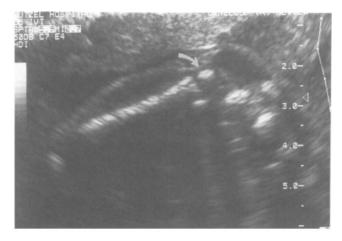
Patient 2, ultrasound imaging of the fetal femus at 21 weeks of gestation demonstrates echogenic epipheses (arrow) suggestive of premature and disorder mineralization.
